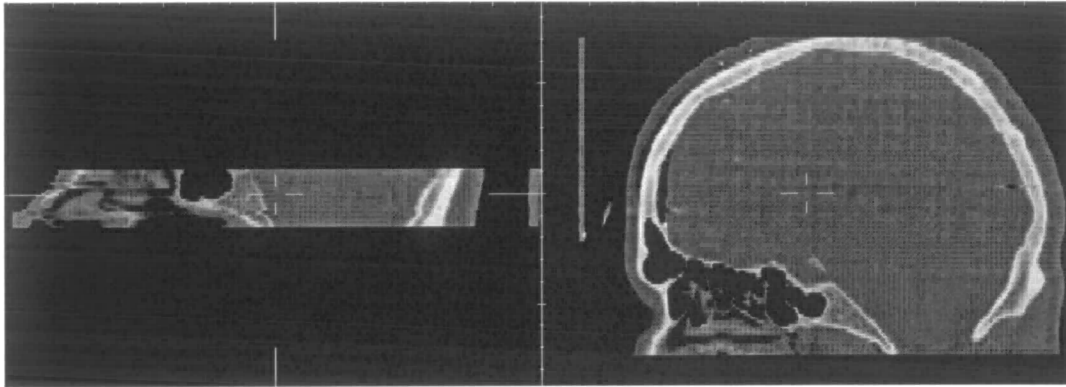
The axial extent of CT brain images varies considerably from full head stereotactic images (W, right) to targeted acquisitions (E, left).
